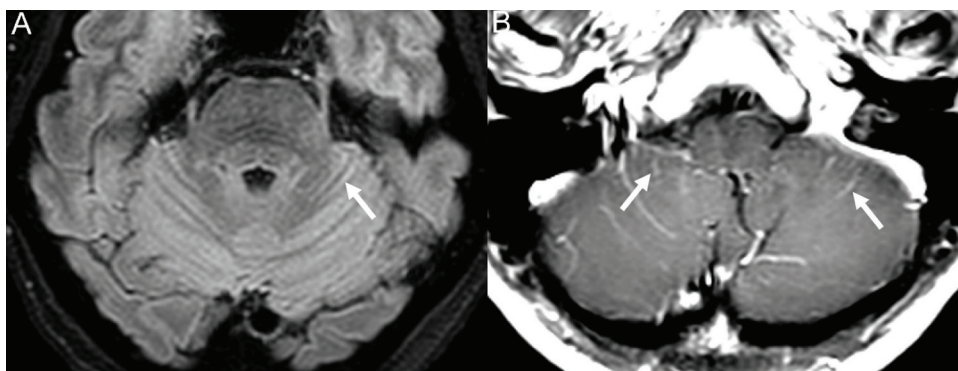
A 56-year-old woman with clinical suspicion of meningitis but normal CSF profile. Presence of leptomeningeal enhancement or subarachnoid space abnormality in cerebellar folia was found in CE-3D FLAIR/FS (arrow) (A) and CE-T1WI (arrow) (B).
